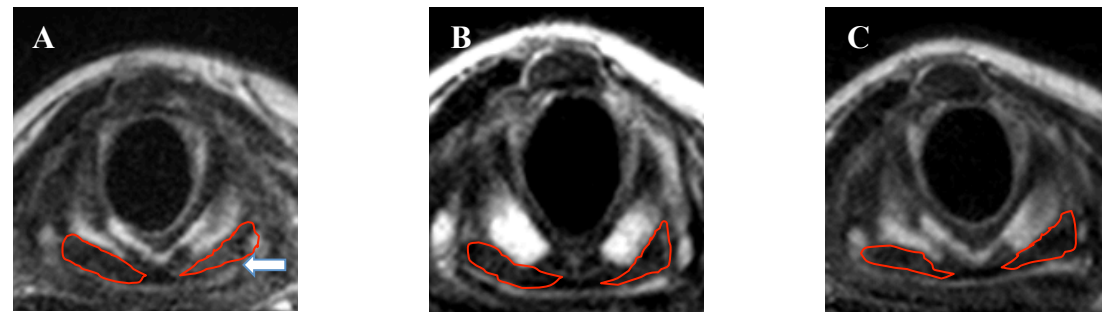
Patient-2 T2-MRI depicting PCA bulk on axial plane at baseline (A); 6- (B); and 12-months (C) post-selective reinnervation. The arrow shows the paralysed side.
